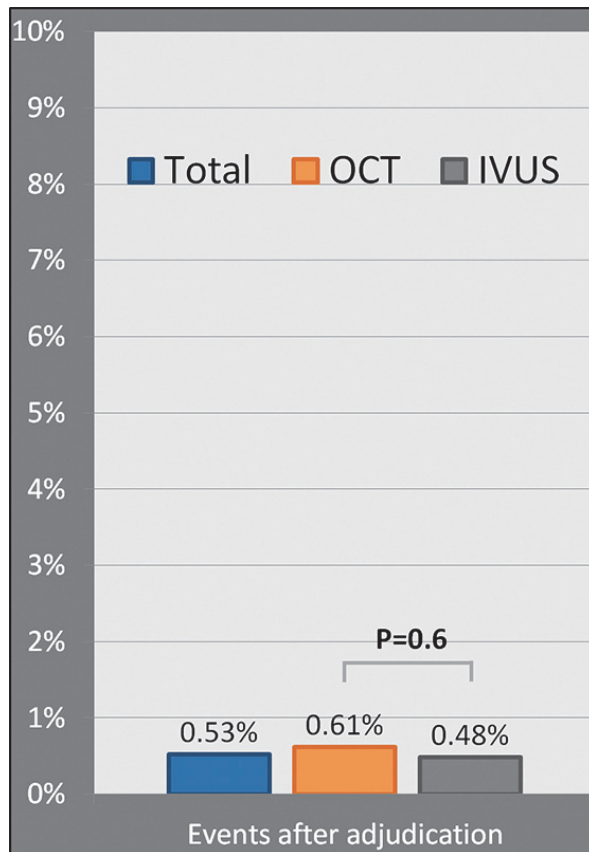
Event rates of intravascular ultrasound and optical coherence tomography after adjudication.
